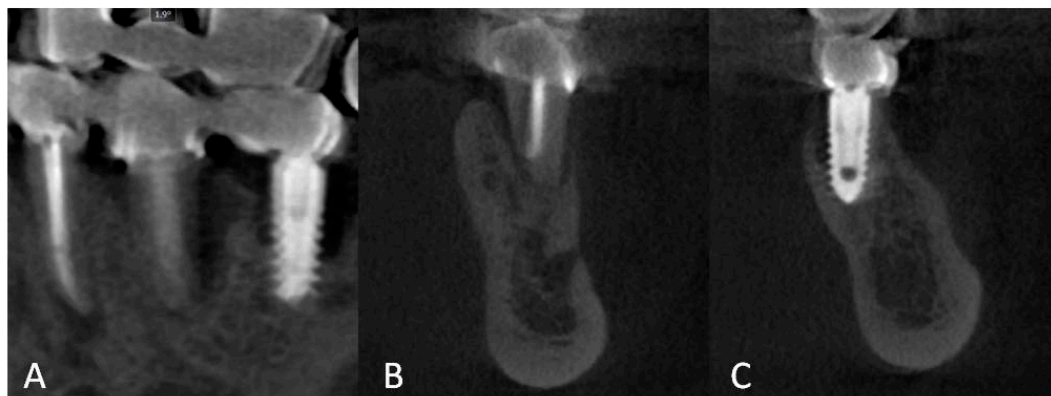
Cone-beam computed tomography (CBCT) analysis (Acteon X-Mind Trium) before surgical treatment showed severe impairment of Region 35 caused by radicular fracture and accentuated peri-implantitis around fixture in Region 36. (A) Curved planar reformation, and cross-sections of Regions (B) 35 and (C) 36.
